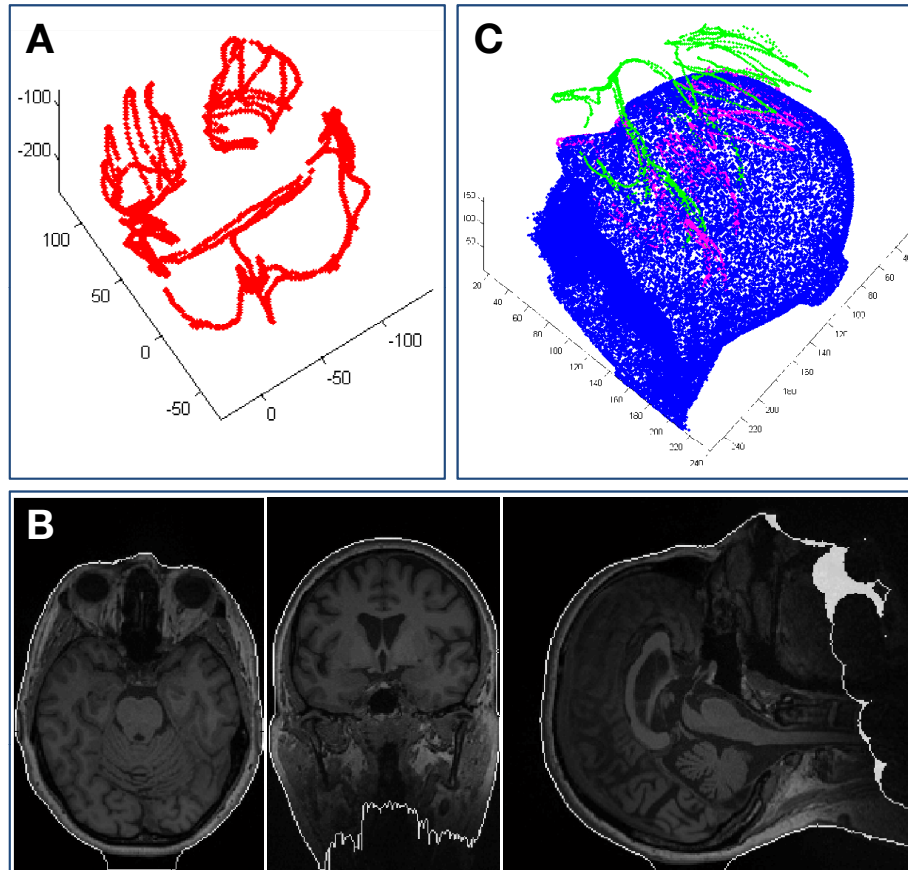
First result from our new multi-modal dataset acquisitions. We obtain 3DUS data (B-mode and RF), as well as different modes of MRI scans. We co-register both datasets optically, by sampling the skin surface in US space (A), as well as roughly segmenting the skin surface in MRI space (bright outlines) (B). The registration of both point clouds is performed e.g. using ICP [26] (panel C, blue point cloud = MRI, green = US skin surface prior to ICP, magenta = US matched to MRI using ICP).
